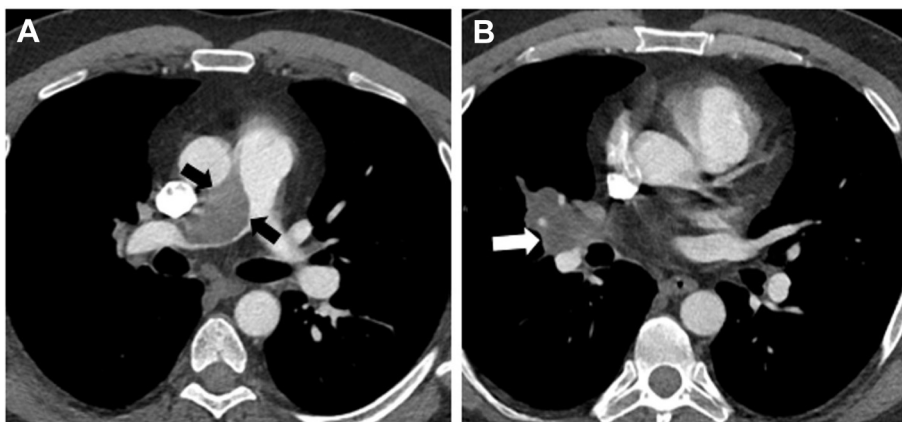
Axial images from CT angiogram of the chest through level of main pulmonary artery (A) and right hilum (B). A, Demonstrates a large filling defect in the right pulmonary artery. The filling defect extends beyond the lumen of the artery, into the mediastinum, distinguishing this mass from a large pulmonary embolism (black arrows). B, The presence of right hilar adenopathy also raises the suspicion of neoplasm (white arrows). Pathology report was consistent with a high-grade intimal sarcoma.
